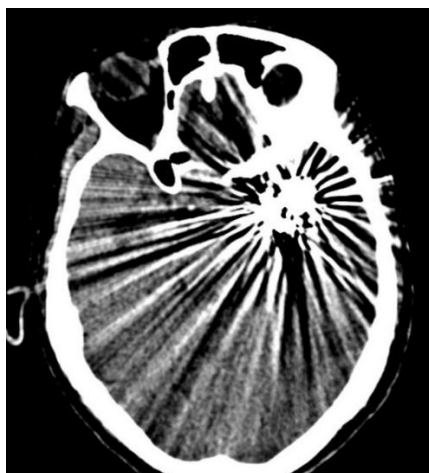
CT Brain with intraparenchymal hematoma with coil artifact from previous coil
